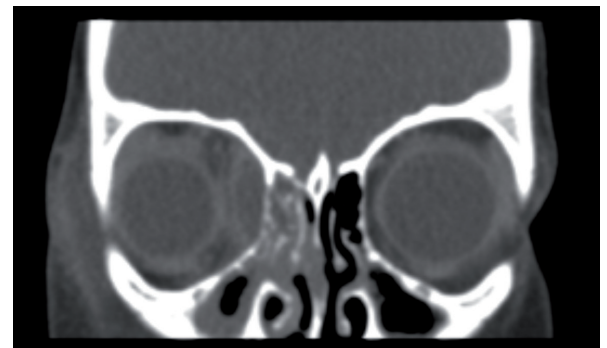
Coronal computed tomography scan showing ethmoid opacification and subperiosteal abscess formation.
